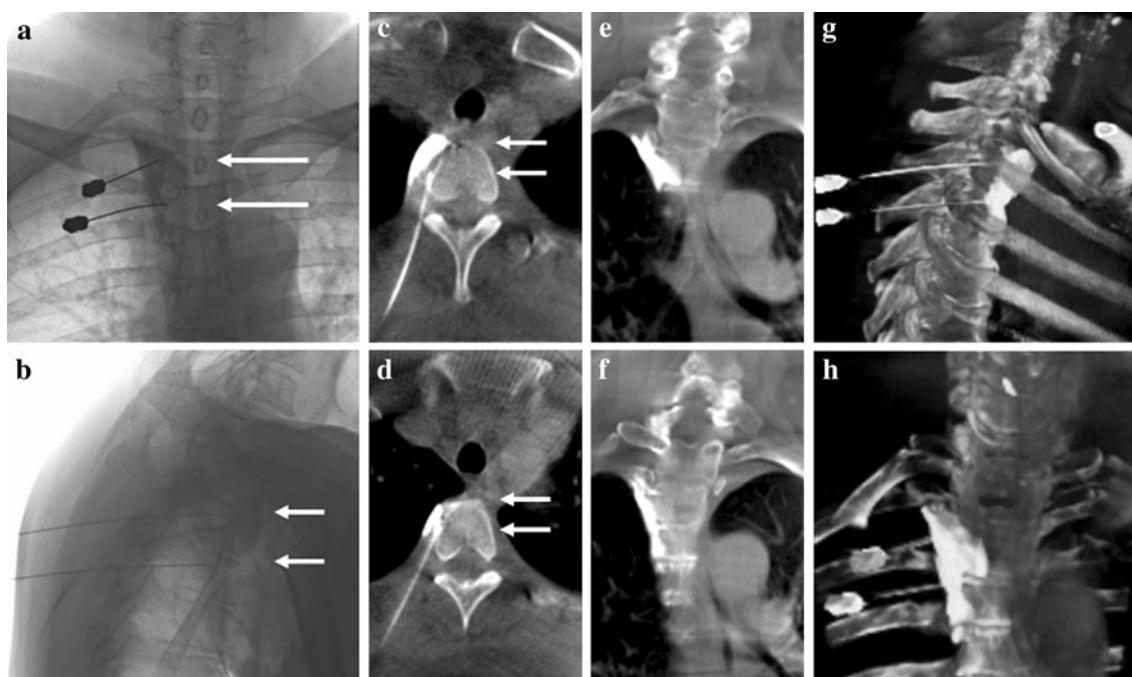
Fluoroscopic images from C-arm fluoroscopic cone-beam computed tomography (CT) in a patient undergoing chemical thoracic sympathectomy (a, b). Transverse images (c, d) and coronal images (e, f) from cone-beam CT are shown. Arrows in a and b indicate levels of c and d, and those in c and d indicate levels of e and f. g, h
